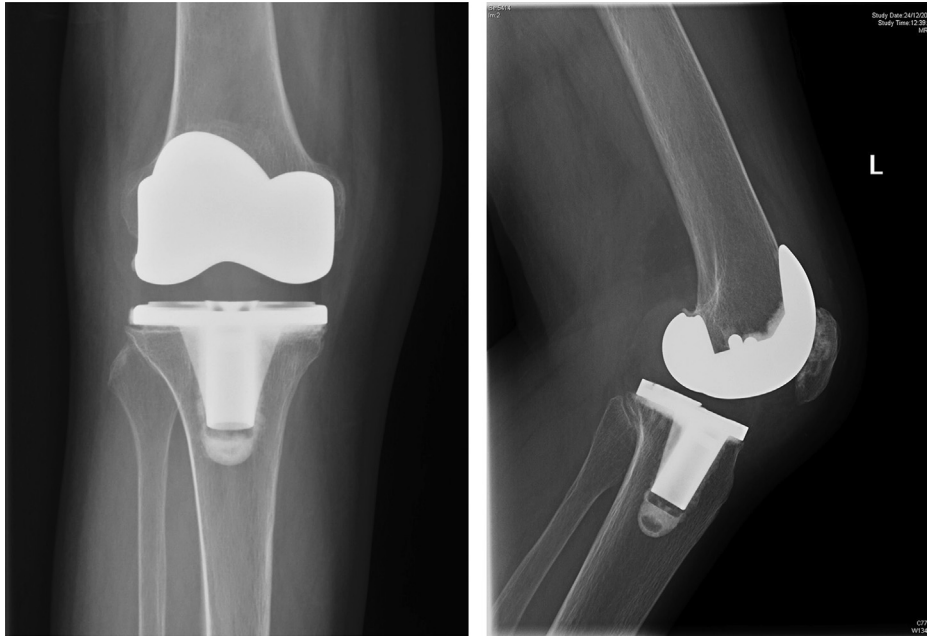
Radiograph of the right knee 1 month after the operation.
